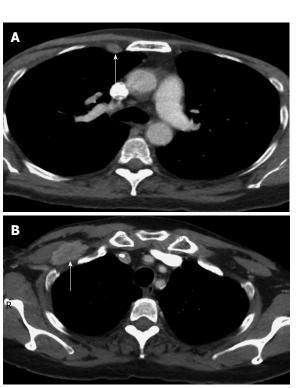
Computed Tomography scan of the chest before initiation of Adalimumab. A: Internal mammary lymph node (arrow); B: Retropectoral lymph node (arrow).
